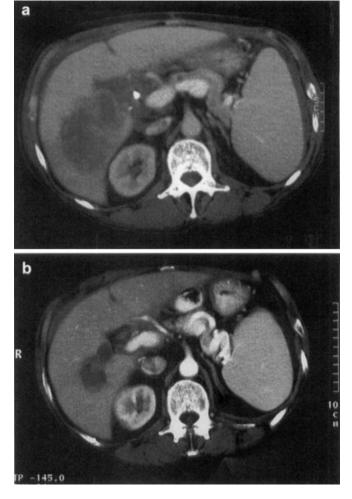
a CT scan of patient 2 showing a large, hypodense tumour involving the hilum of the liver. b Post-treatment CT scan of the same patient, demonstrating distinct regression of the tumour
